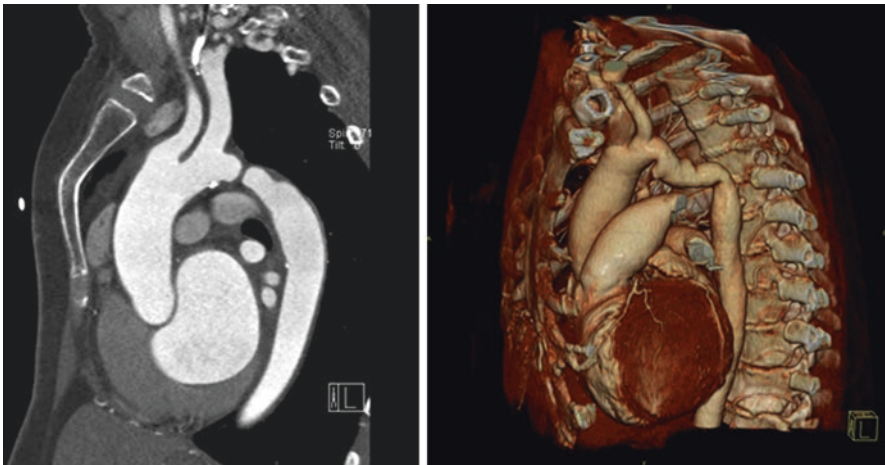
Various forms of aorta coarctation CT images of a patient with aorta coarctation. These images demonstrate the different morphology in aorta coarctation from discrete stenosis to tubular hypoplastic segment, complex 3D tortuous anatomy
